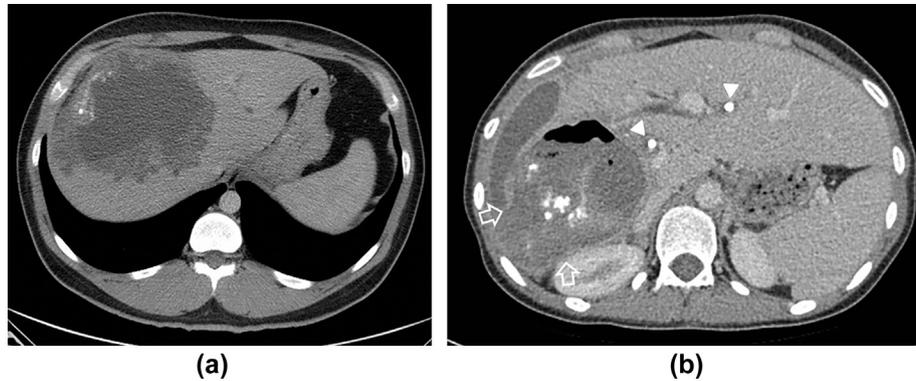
CT as a useful tool to identify and evaluate patterns of (a) peripheral and (b) central lesion calcification. Note how in (b) CT demonstrates extension through the hepatic capsule (white arrows) and formation of a perihepatic collection. Intra-ductal high density (white triangles) consistent with biliary drainage tubing. There is slight irregular marginal enhancement.
